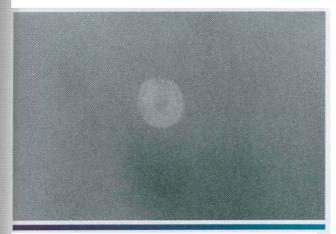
• Sialolithiasis. Soft tissue radiograph of the same lesion depicted in Figure 11 - 15. A laminated calcified mass is revealed.
